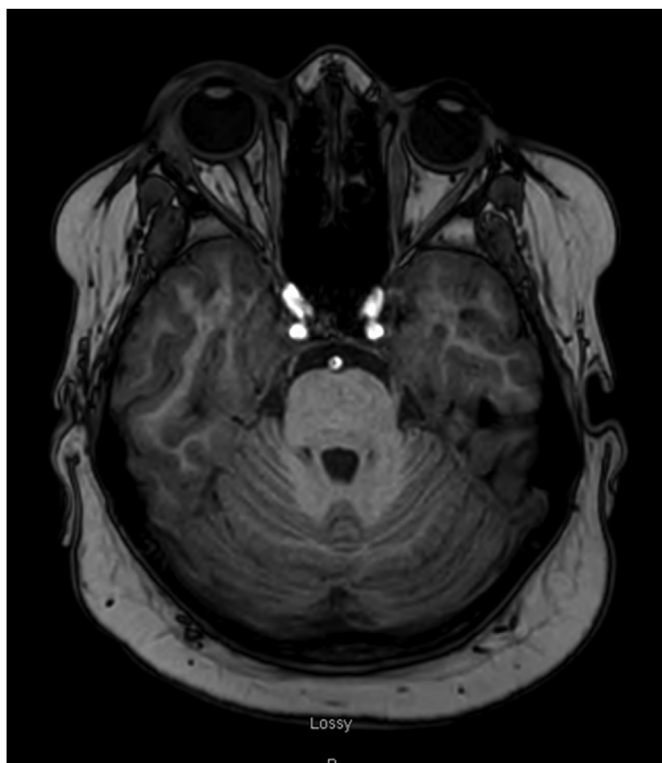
Axial view of a T1 weighted MRI of the brain. Demonstrates enlargement of the right and left medial rectus. There is also pre and post septal edema present on the right.
